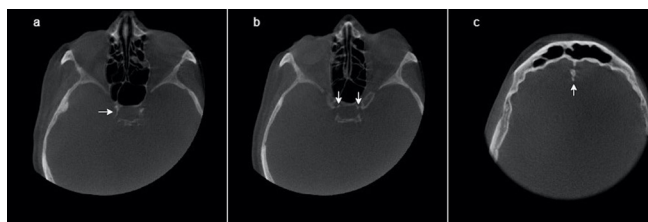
Axial CBCT images demonstrate (a) interclinoid ligament calcification (arrow), (b) caroticoclinoid ligament calcification (arrows), (c) falx cerebri calcification (arrow).
